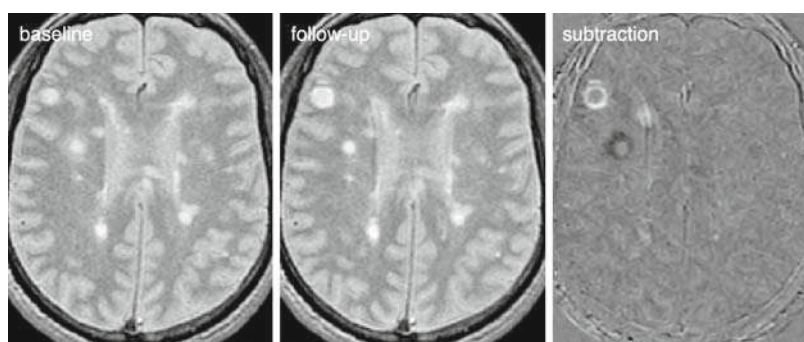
Example of structural change detected by serial MRI. A subtraction of co-registered and intensity-normalized baseline and follow-up exam reveals both new and resolving pathology, visible as hyper- and hypointensity, respectively, relative to the neutral gray. Changes are highlighted as all stable anatomy cancels in the subtraction
